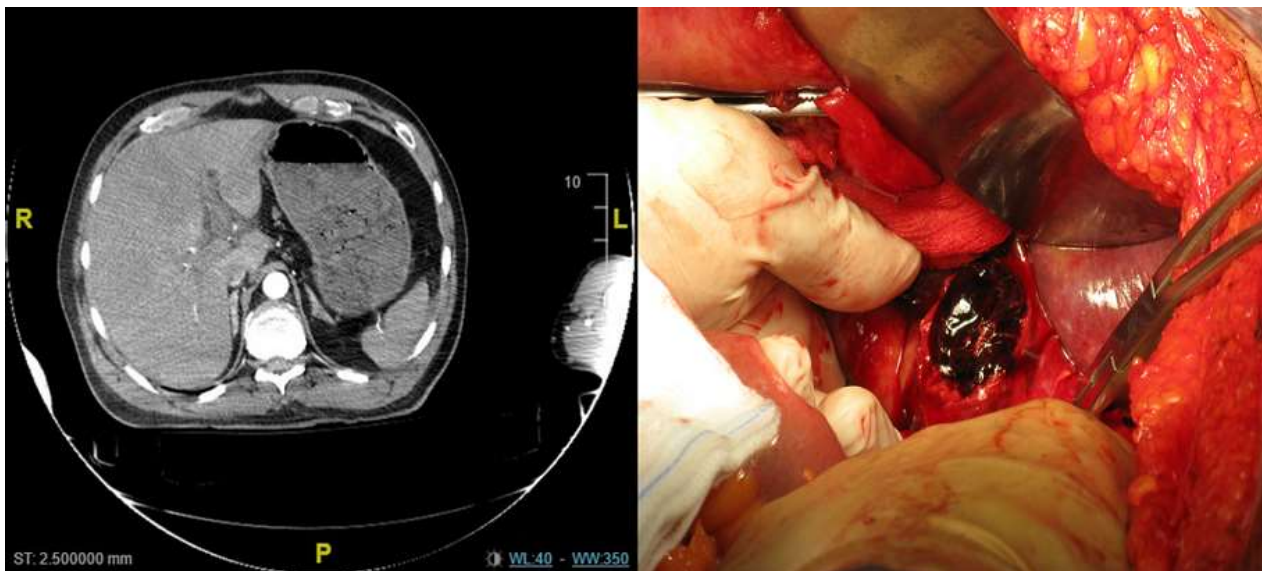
computed tomography angiography (CTA); multiple hepatic contusion, at laparotomy hematoma of the hepatic artery
